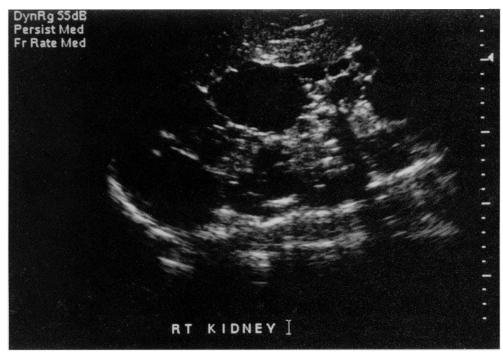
Ultrasound of right kidney showing multiple cysts.
